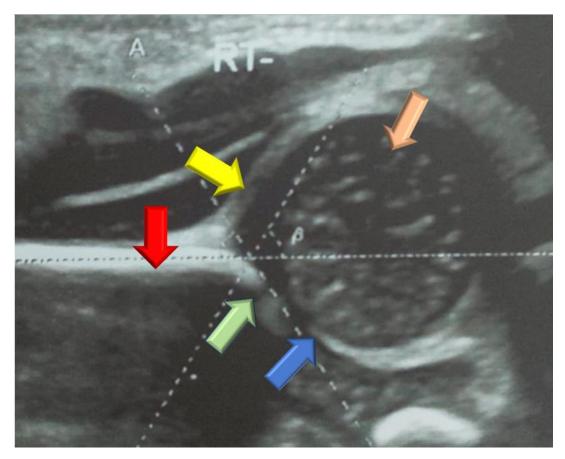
An ultrasound image from the current study indicating anatomical landmarks with arrows of different colors. Light green arrow-Bony acetabular roof, Yellow-labrum, Red arrow-Iliac bone, Blue arrow-Triradiate cartilage & Orange arrow-Head of femur.
